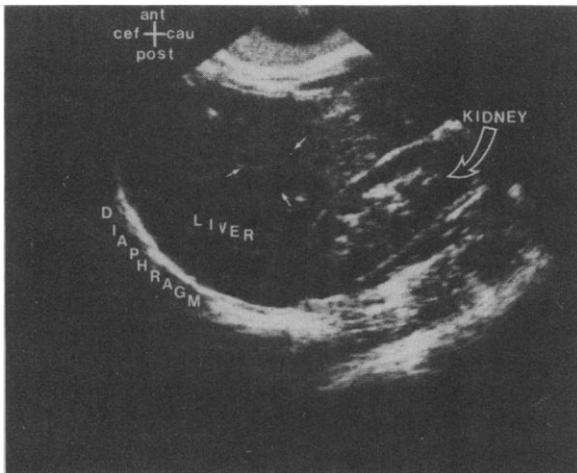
Abdominal sonogram showing the liver, kidney, and diaphragm in sagittal section. Small arrows indicate blood vessels within the liver. Abbreviations: *ant*, anterior; *cau*, caudad; *cef*, cephalad; *post*, posterior.
